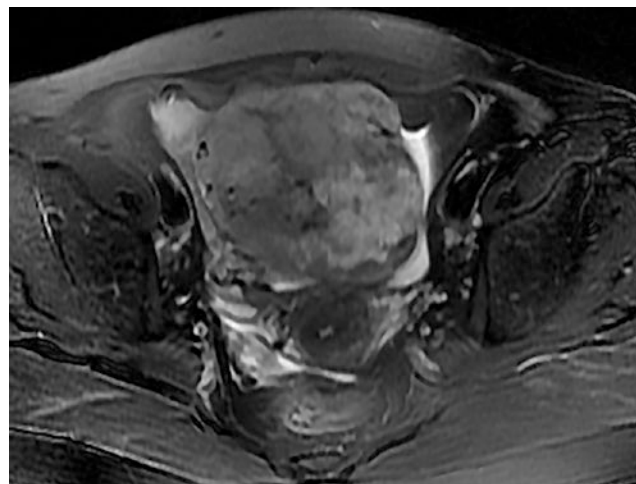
T2-weighted with fat suppression image showed the mass had heterogeneous high signal intensity
